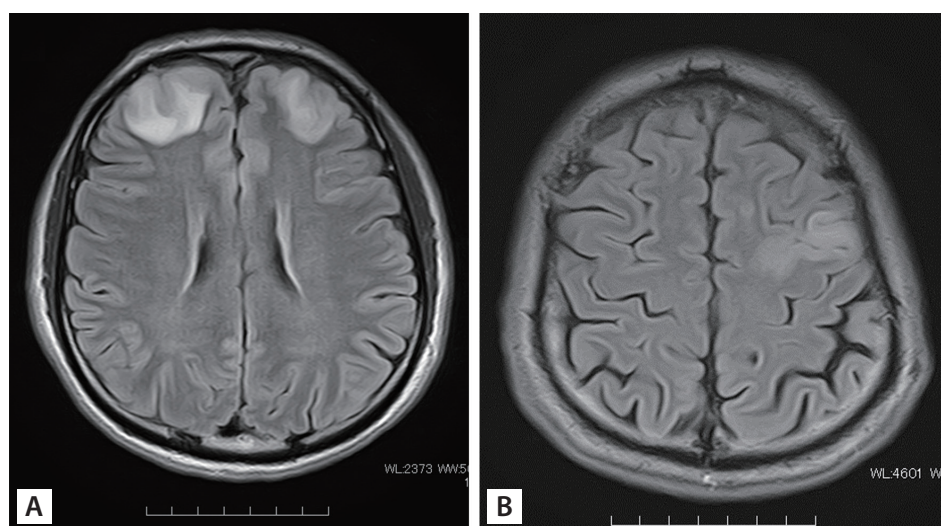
(A) Magnetic resonance imaging (MRI)/fluid-attenuated inversion recovery (FLAIR) imaging showing hyperintense lesions in the bilateral frontal lobes on the day of admission. (B) On day 12 of the illness, MRI/FLAIR imaging of the head showing a new high signal in the left frontal lobe.
